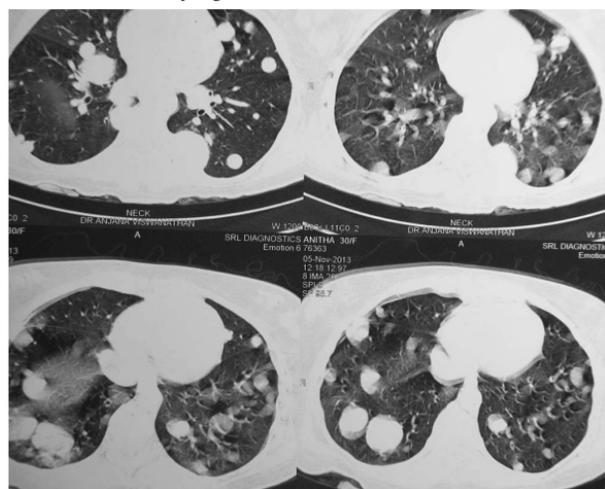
CT Chest showing multiple nodules in random distribution and masses
